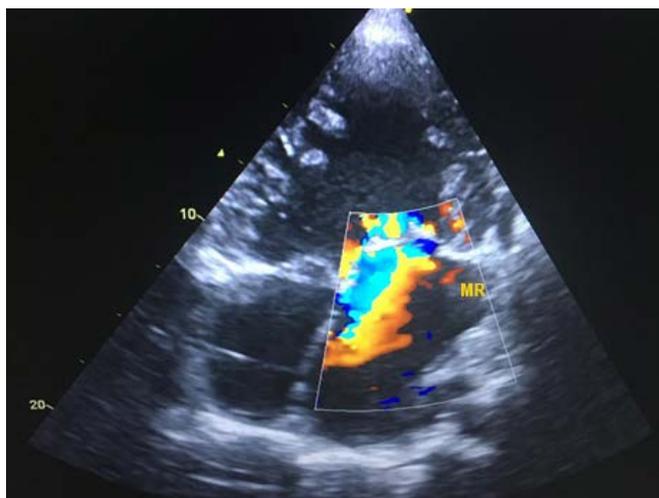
Transsthoracic echocardiography: apical view, demonstrating two atrioventricular valves, interatrial septum and mitral regurgitation. 361x270mm (72x72 DPI).
